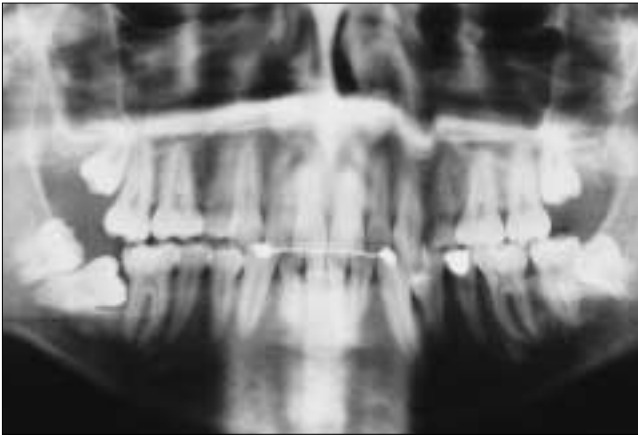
Panoramic radiograph revealing horizontally impacted teeth 47 and 48. Note the stage of root formation of tooth 48.
